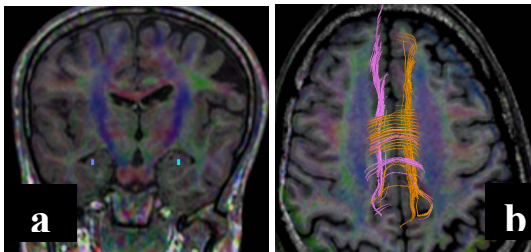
Nine year old male with epilepsy. Conventional brain MRI was unremarkable (not shown). a) DTI color map overlaid on coronal FLAIR, b) DTI tractography for cingulum overlaid on axial image. ROIs were plotted on the hippocampus and ILF on both sides. There is substantial difference in the FA and diffusivity values between both sides, with decreased FA and increased ADC values on the right side in the hippocampal regions and cingulum. Findings are suggestive of right mesial temporal sclerosis. These were consistent with advanced EEG findings.
